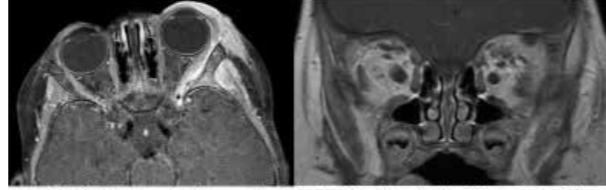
Initial MRI demonstrating enhancement along the lateral orbital wall extending through the greater wing of the sphenoid
